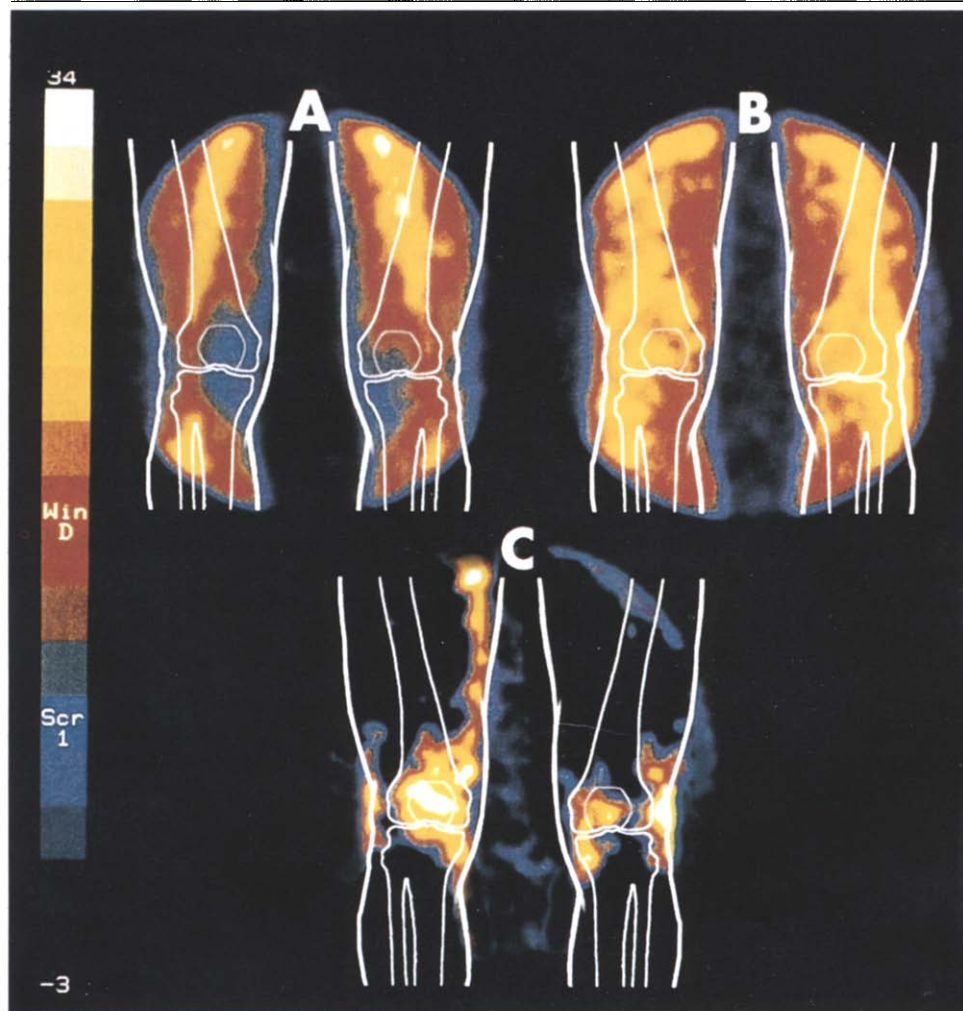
(A) SPECT analysis of lower limbs 2 h after intravenous administration of ^{99m}Tc sodium pertechnetate. (B) SPECT analysis of lower limbs 2 h after intravenous administration of CS labeled with ^{99m}Tc . (C) Difference between B and A.
